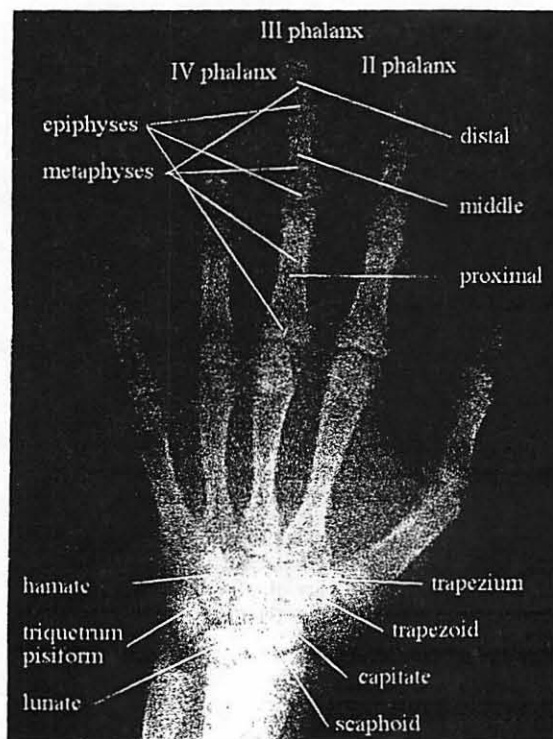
Hand radiograph with anatomical structures of phalanges.
